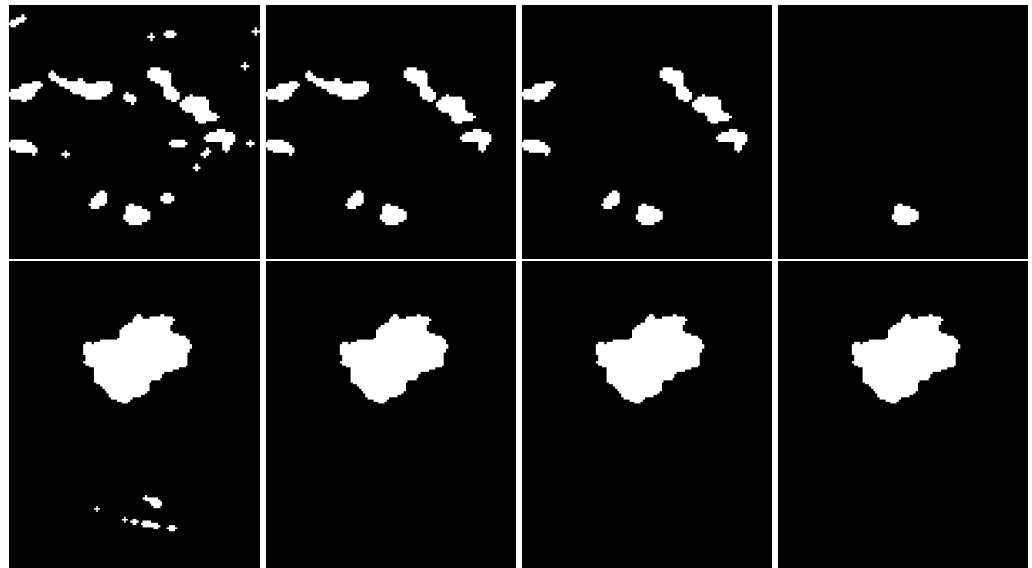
Examples of post-processing steps on two breast lesions (one per row): (1st column) binary mask obtained after sFCM clustering; (2nd column) mask after the small-area removal; (3rd column) mask after both the small-area removal and the eccentricity-based selection; and (4th column) mask after ratio criteria, defined in Equations (18) and (19). With respect to the position in the DCE-MRI sequence, all images have been rotated 90° clockwise, in order to improve the graphical representation and allow all the images, related to a specific lesions, to be displayed in a single line.
